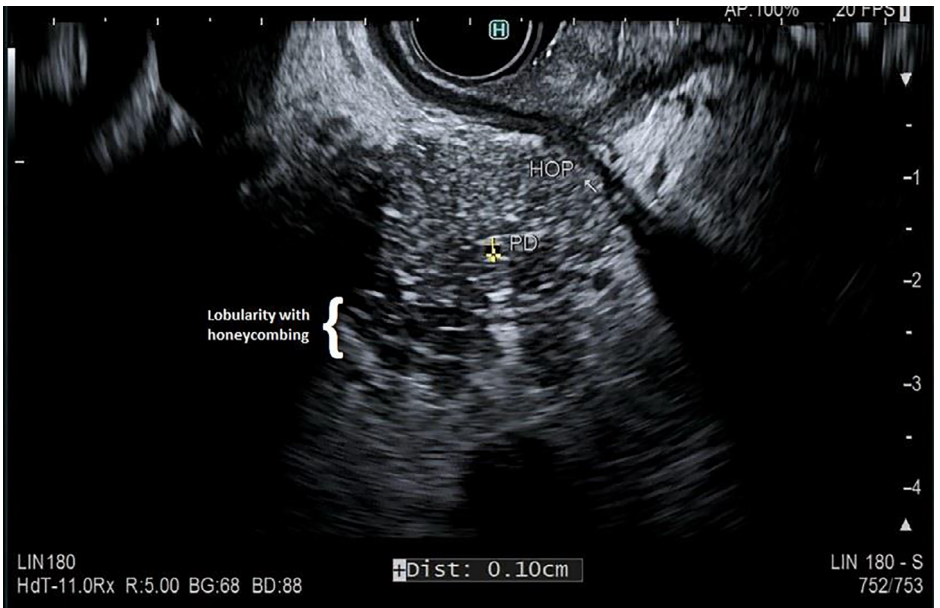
Endoscopic Ultrasound showing lobularity with honeycombing of the pancreas
